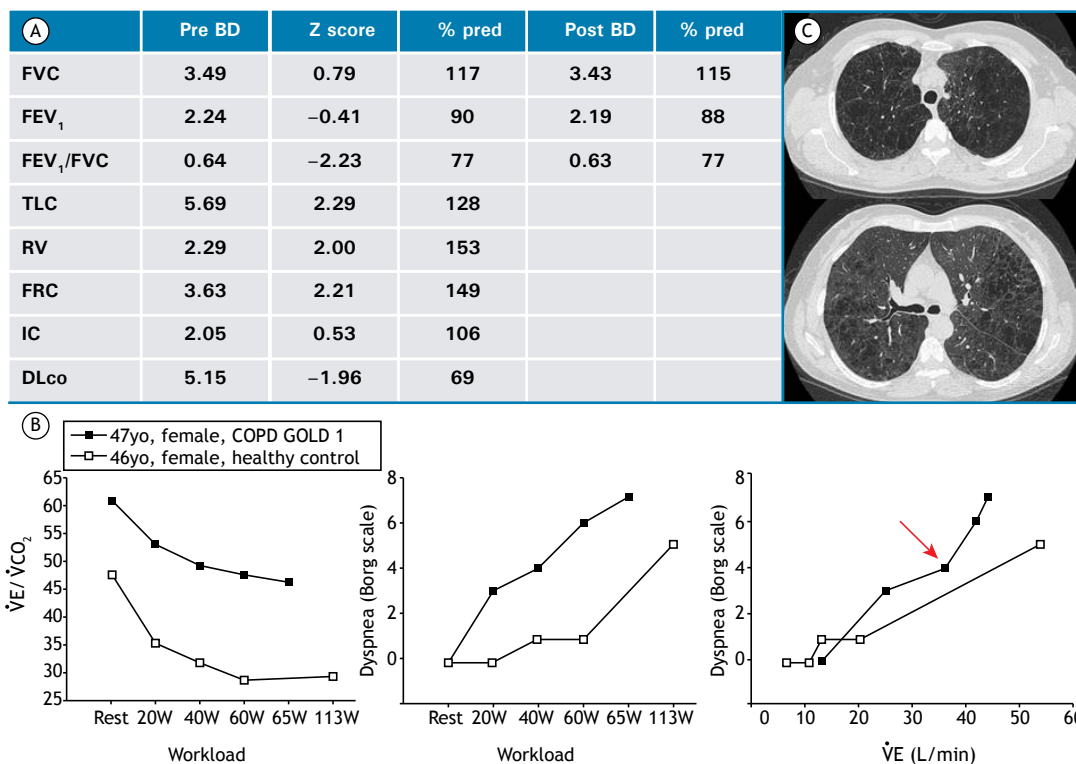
Data of a 47-year-old female smoker with out-of-proportion dyspnea and mild COPD. In A, lung function results with the patient at rest, In B, ventilatory response and dyspnea perception during incremental cardiopulmonary exercise testing. In C, chest CT scans showing extensive emphysema. BD: bronchodilator; FRC: functional residual capacity; IC: inspiratory capacity; yo: years old; GOLD 1: FEV₁ ≥ 80% of predicted; V̇_E: minute ventilation; and V̇CO₂: carbon dioxide output.
